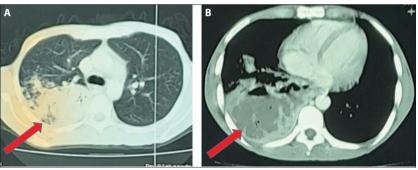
Case 3; thoracic computed tomography: (A, B) – the entire lower lobe of the right lung is occupied by a large liquefied lesion containing air, measuring approximately  $10 \times 20$  cm in cross-section – a lung abscess; a small pleural effusion is visible in the right basal pleura
